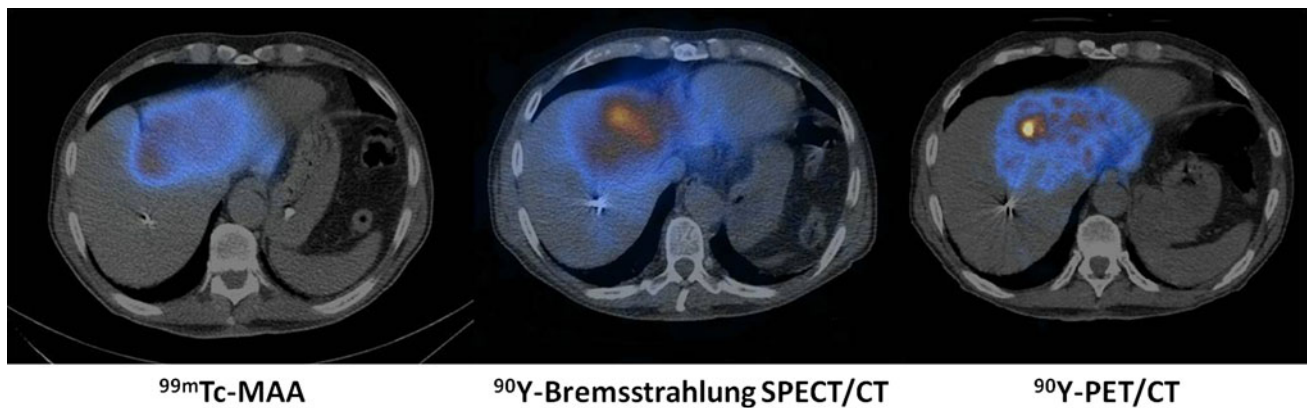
Pretreatment ^{99m}Tc -MAA scintigraphy and post-treatment SPECT/CT and PET/CT of ^{90}Y microspheres show comparable biodistribution (color figure online)
